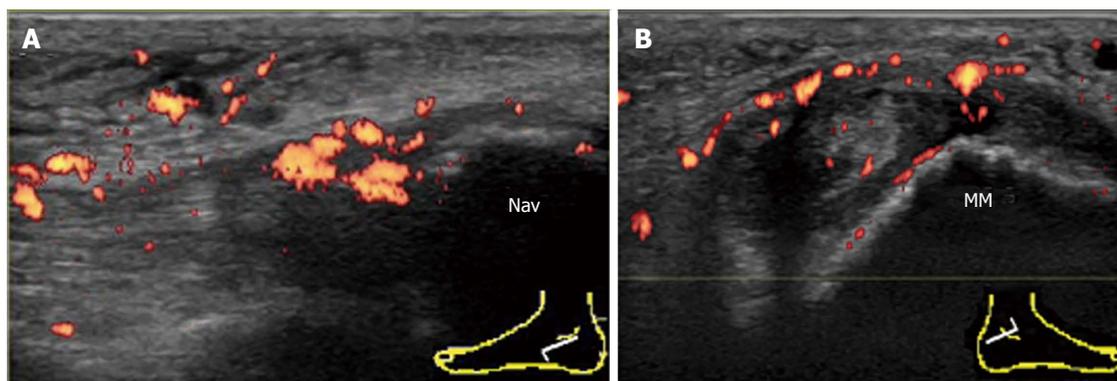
Involvement of the tibialis posterior tendon in psoriatic arthritis. A: Enthesitis of the TP at the navicular insertion in psoriatic arthritis. Longitudinal power Doppler sonogram of TP shows intratendinous hypoechoic change and loss of the fibrillar echoes with hyperemia adjacent to the insertion into the navicular bone. Cortical irregularities of the navicular bone at the insertion are also depicted; B: Tenosynovitis of the contralateral TP in the same patient. Transverse power Doppler sonogram at the level of the tip of the medial malleolus shows thickening and hyperemia of both the tendon sheath and the flexor retinaculum. Cortical irregularities of the medial malleolus are also depicted. Nav: Navicular bone; MM: Medial malleolus; TP: Tibialis posterior.
